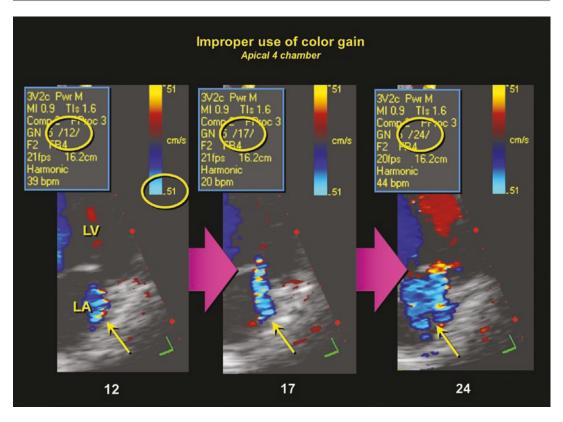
Three panels from a subject with trivial mitral regurgitation from the apical four-chamber view showing artifactual increase in jet size with increase in color flow gain. This is the same patient as in Fig. 10.56
